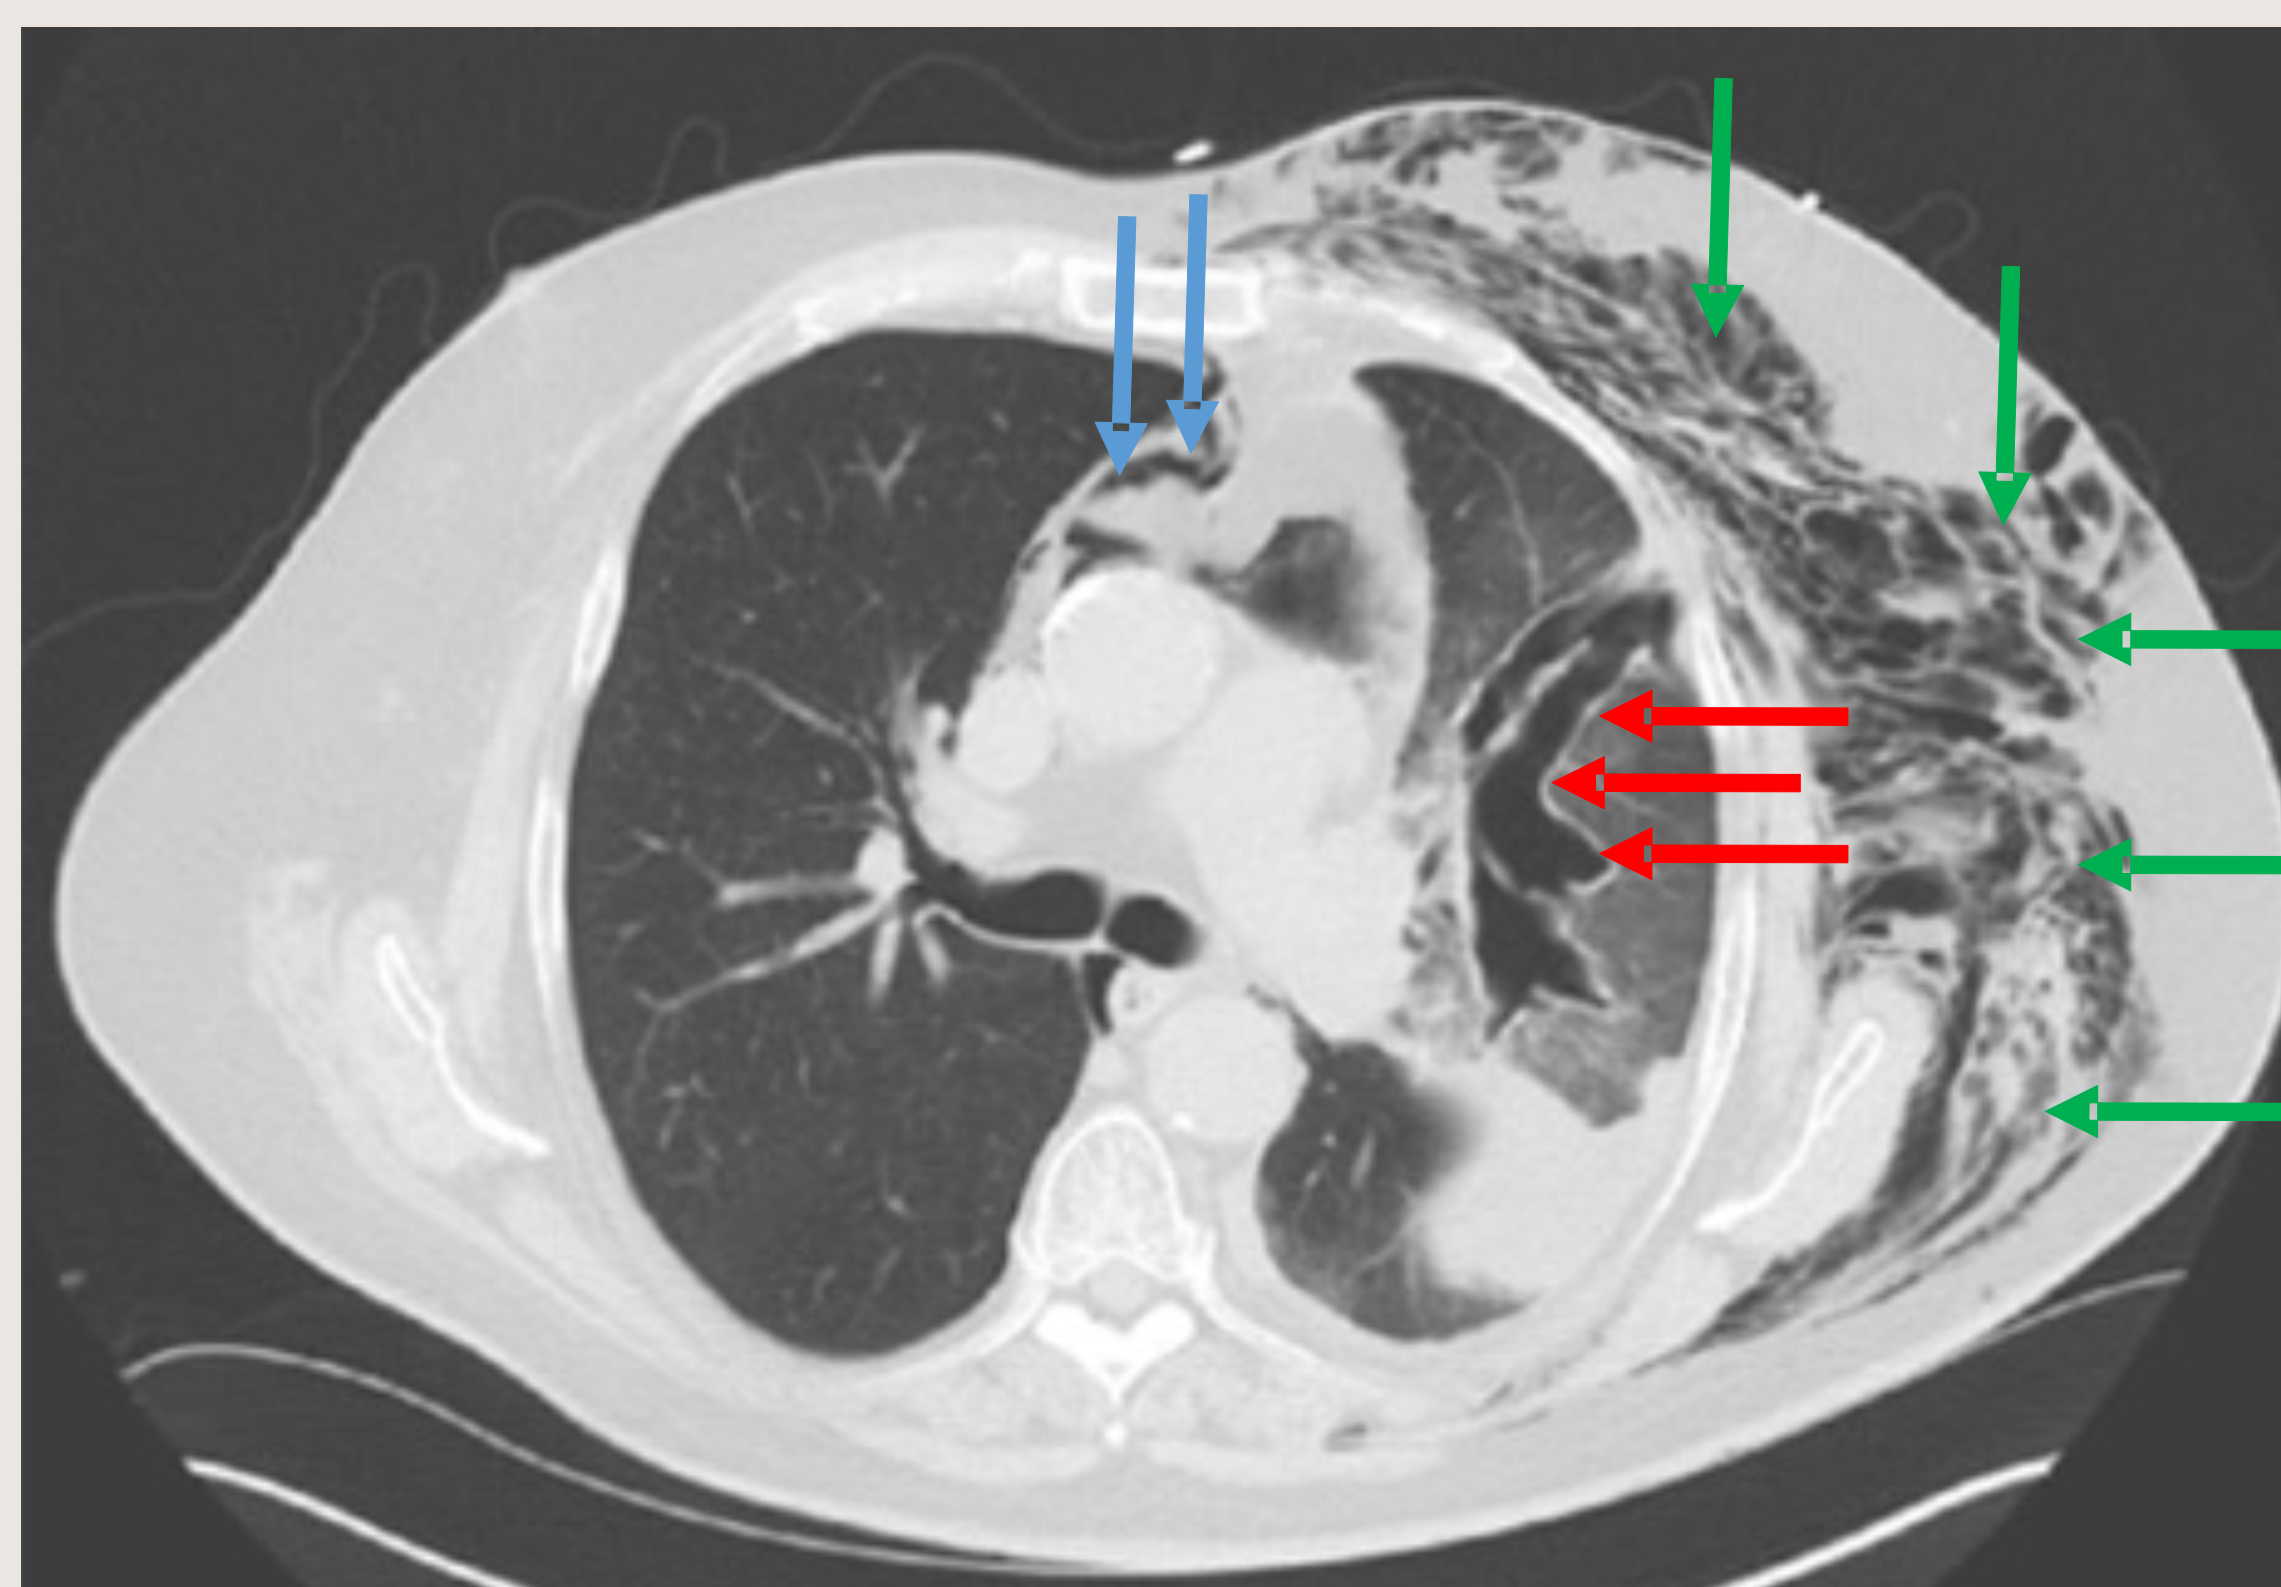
CT thorax showing contained area of air in left lung (red), that extends to the mediastinum (blue) as well subcutaneous chest tissue (green)
